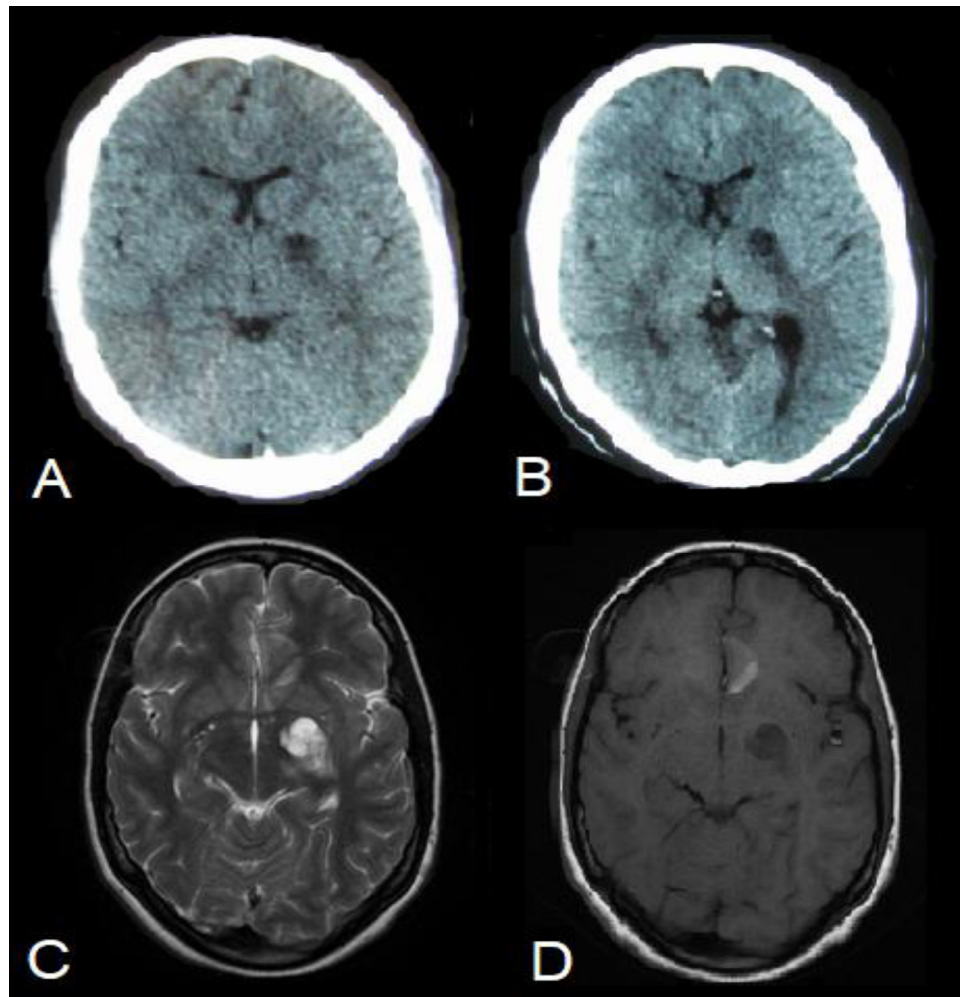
Brain computed tomography (CT) and magnetic resonance imaging (MRI) axial scans. (A) CT scan at arrival with a hypodense lesion in the left internal capsule. (B) Persistence of lesion on day 11. (C) T2-weighted and (D) T1-weighted MRI scans at day 12 with a non-enhancing cystic lesion in the left gangliocapsular region with adjacent edema, suggestive of cryptococcoma.
